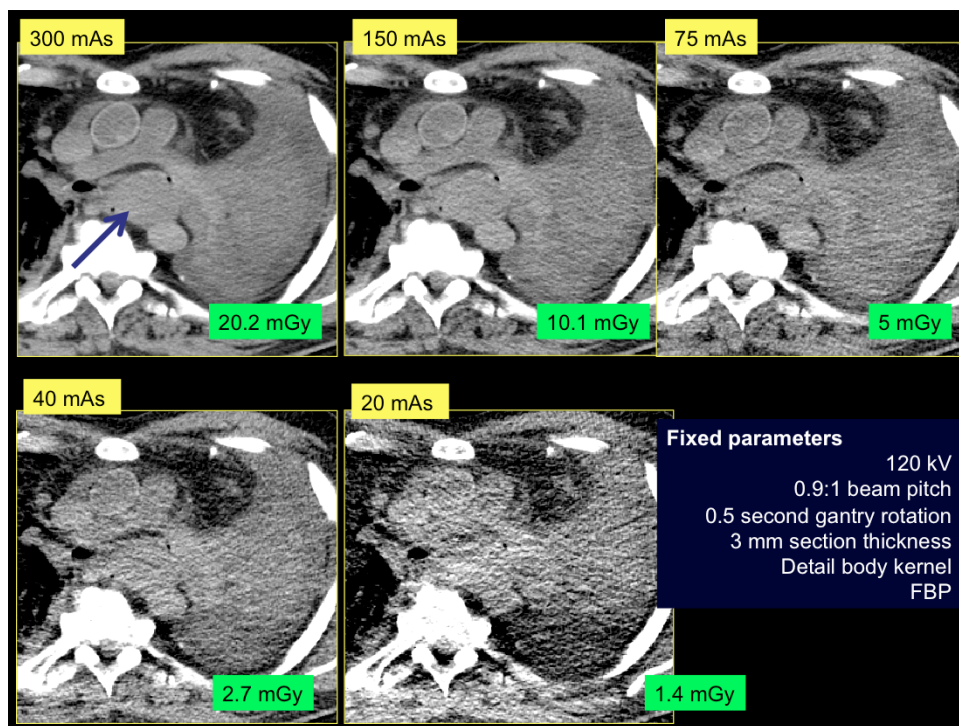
A 70 year old male (89 kg) with post mortem chest CT at various tube currents. The 75 mAs (CTDIvol 5 mGy) image shows 6.5 * 4 cm mediastinal mass (arrow) located posterior to pulmonary artery bifurcation, superior left atrium and anterior to descending aorta, with additional findings of collapsed left lung and pleural effusion. Further reduction of tube current (40 and 20 mAs) results in increased image noise affecting the detection of edges of the mediastinal mass as well as left pleural effusion. The lesson here is that for mediastinal abnormalities higher dose is necessary as compared to primary lung abnormalities. Tailoring of CT protocols based on clinical indications is important. For screening protocols or primary lung pathologies much lower dose CT is sufficient, whereas in patients with advanced disease or mediastinal abnormalities, a higher dose may be necessary. Once again, addition of intravenous contrast would have improved the contrast to noise ratio of the mediastinal lesions at lower dose images.
